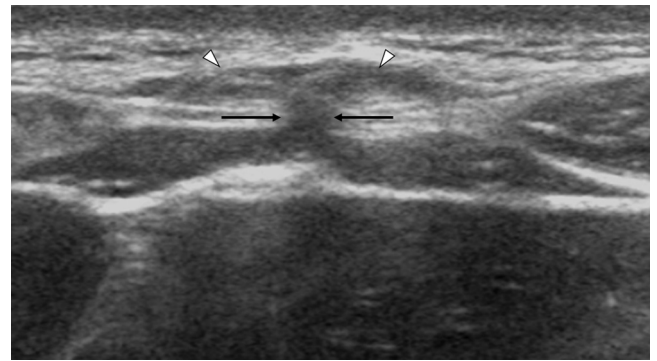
Linea alba defect hernia. Transverse sonogram of the epigastrium. There is herniation of the preperitoneal fat (arrowheads) through a defect in the linea alba (arrows) into the deep subcutaneous tissues.
